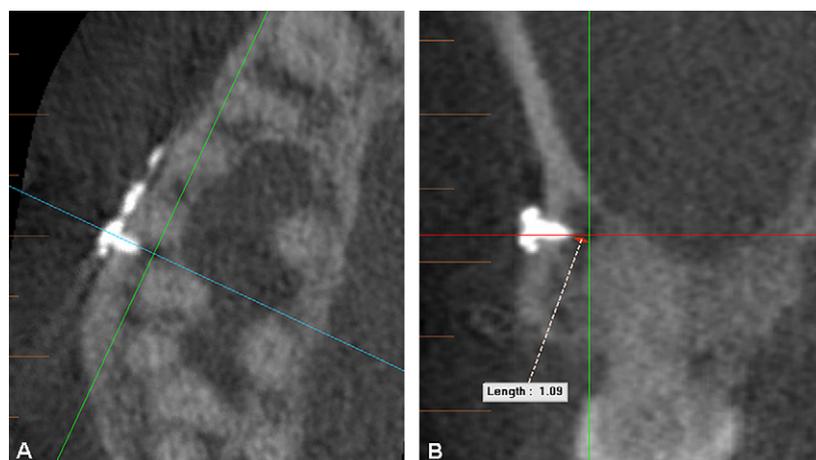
CBCT view of the miniplate with no root contact with the miniscrew: A, axial view; B, frontal view.
